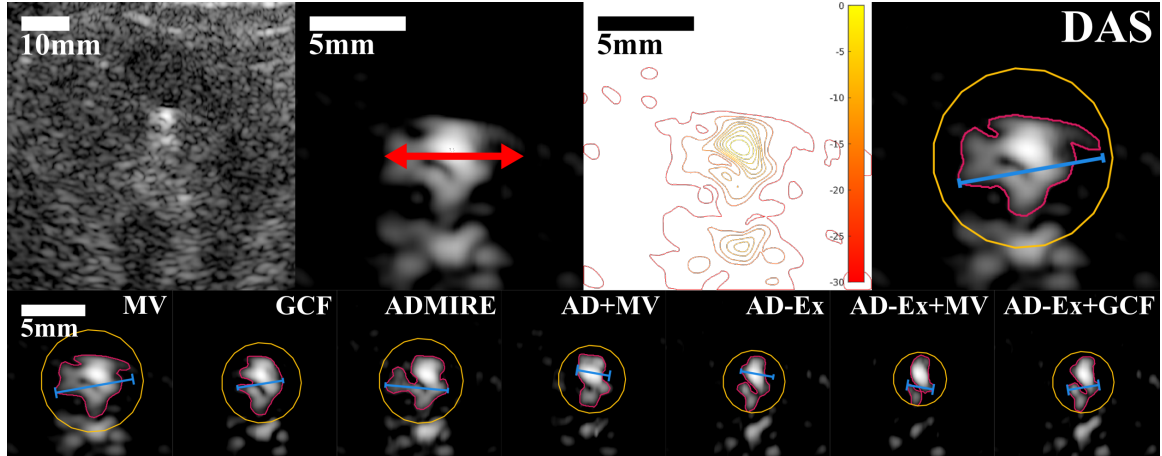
Example of the sizing process for *in vivo* kidney stone Case 1 (CT size of 2.3 mm). The top row shows the process for DAS, starting with the full kidney image on a 50 dB scale. The zoomed images are shown at 30 dB and were used for sizing. The red arrows show the physician-marked stone size, which was used in combination with the contour map to manually circle the stone region for measurements, marked as the red outline. The ultrasound images were acquired such that the stone's longest dimension is on the lateral axis, so we calculated the stone size as the longest distance within $\pm 10^\circ$ of that axis, marked as the blue line. The yellow line shows the region used for the background, which is automatically selected as a circular region double the area of the stone region. The bottom row shows the end results for the same case for MV, GCF, ADMIRE, AD+MV, AD-Ex, AD-Ex+MV, and AD-Ex+GCF. Figure ©2022 Ultrasonics.
